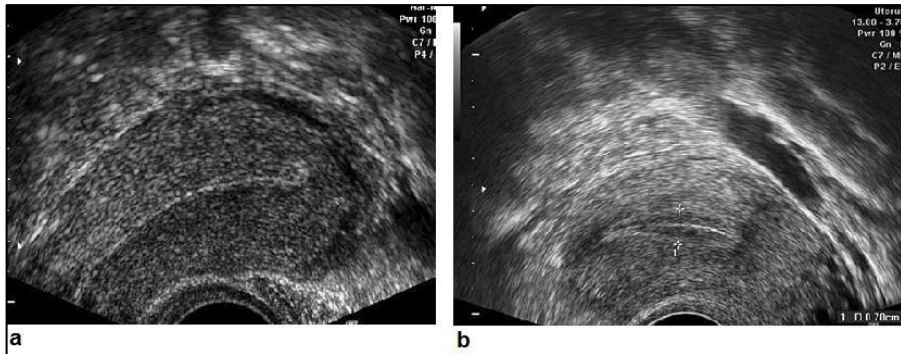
Endovaginal ultrasonography. (a) uterine cavity line (arrow), (b) endometrium thickness (double layer) (*Quoted from Mihiu and Mihiu, 2011*).
